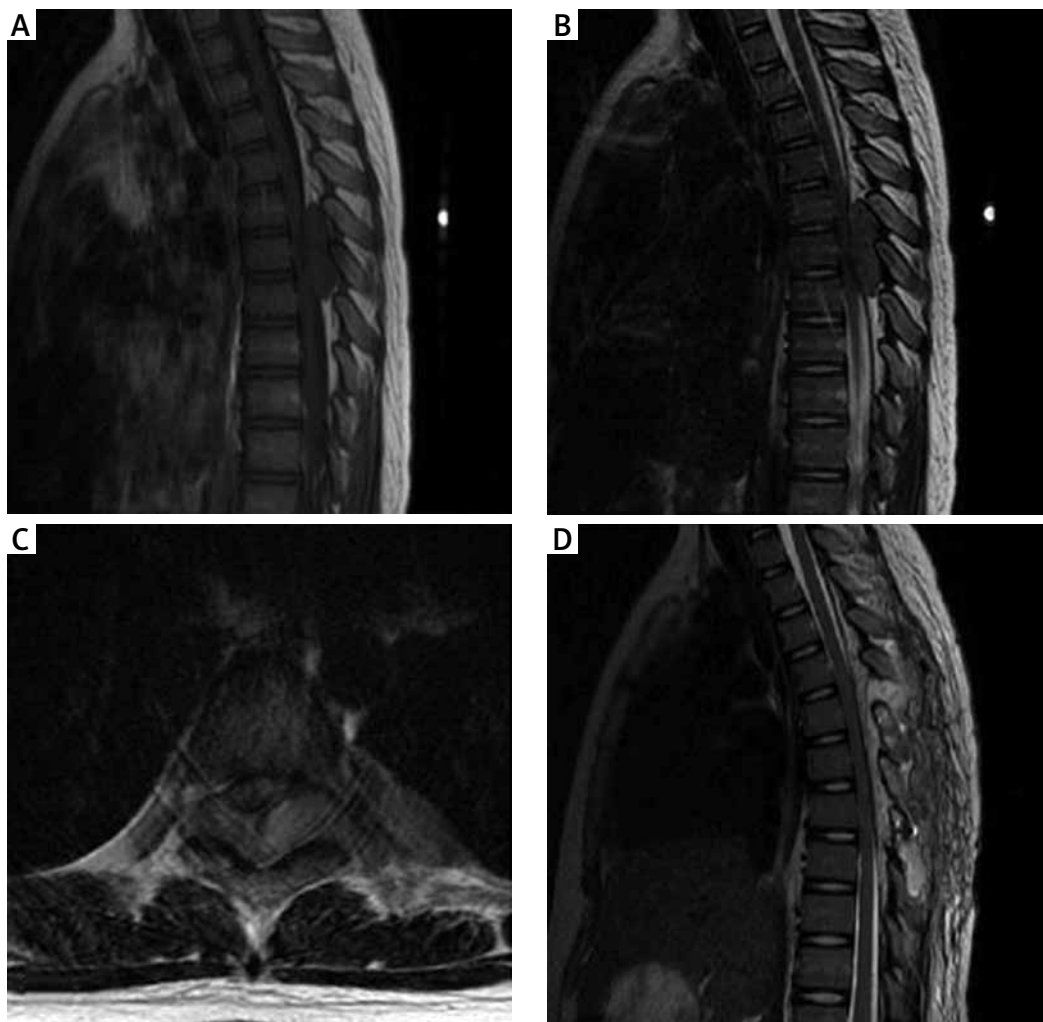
Preoperative MR imaging. A) Sagittal T1-weighted MRI; B) Sagittal T2-weighted MRI; and C) Axial T2-weighted MRI shows a space-occupying lesion at the T5-T7 level. D) Post-operative sagittal T2-weighted MRI.
